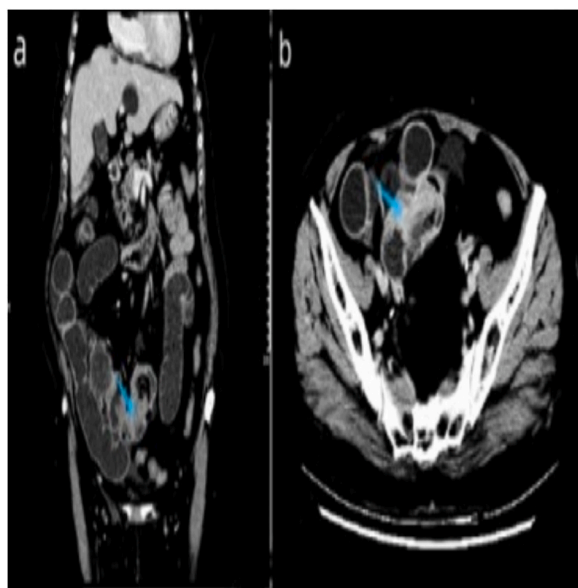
a. Coronal CT scan showing invaginated mesenteric vessels and mesenteric fat (arrow). Fig. 1b. Axial CT scan showing an intraluminal enhancing lesion at the lead point of the intussusception (arrow).
